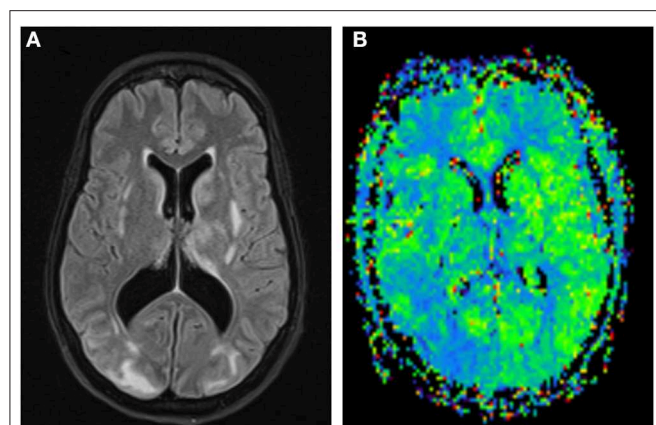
FLAIR images of a PRES case with white matter hyperintensities more prominent in the right occipital lobe (A); MR Perfusion shows reduction in MTT in the right occipital lobe suggestive of hyperperfusion (B).
